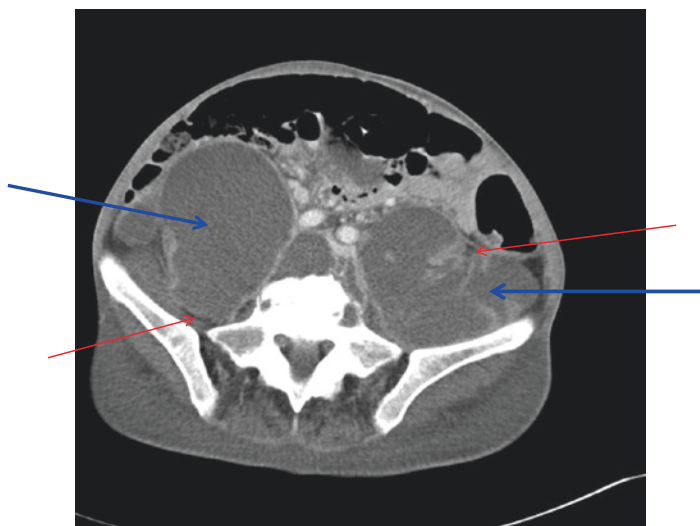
Axial CT cut showing bilateral massive psoas abscesses (blue arrows). These are seen as hypodense, ring-enhancing lesions. This CT cut also demonstrates air within the abscesses (red arrows), a common finding in iliopsoas abscesses
